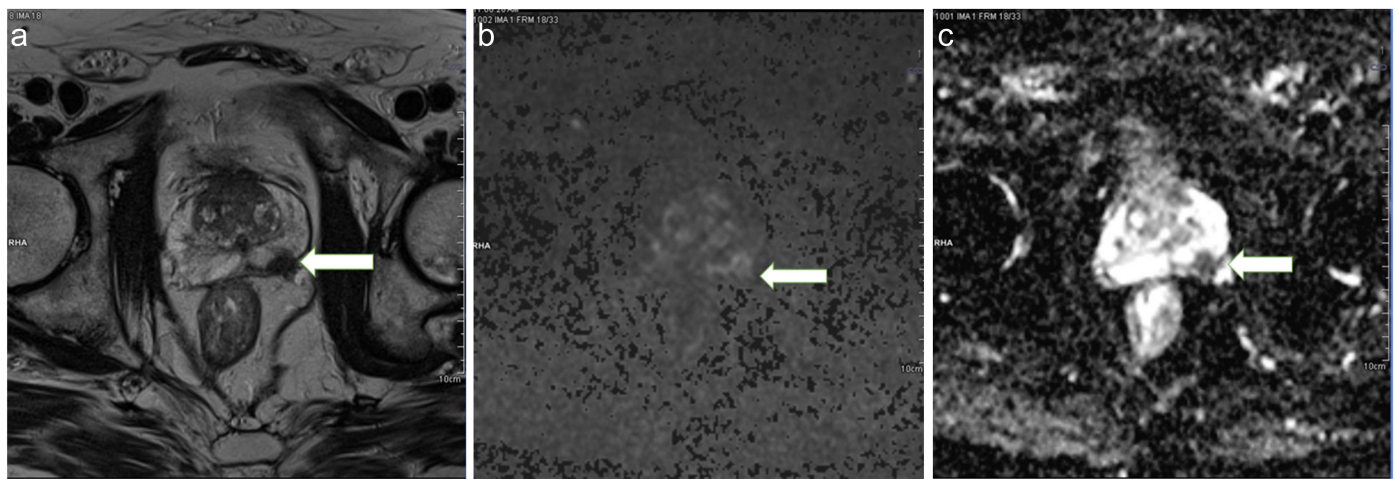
PIRADS 5 cases diagnosed with prostate adenocarcinoma. a) Axial T2W image shows hypointense nodular lesion and extraprostatic extension in the left peripheral zone (white arrow). b) Calc. 1400 DWI, c) ADC map shows diffusion restriction of the lesion (white arrow).
